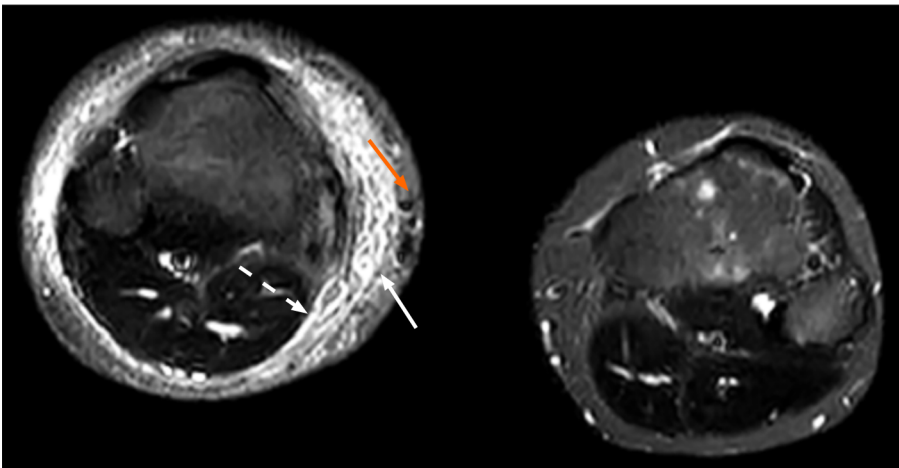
Short time inversion recovery sequence transverse section of lower limb magnetic resonance imaging: Signs of lymphedema in subcutaneous soft tissue, including the honeycomb sign (white arrow) and band sign (white dashed arrow). Thickened, tortuous and dilated veins were observed (orange arrow).
